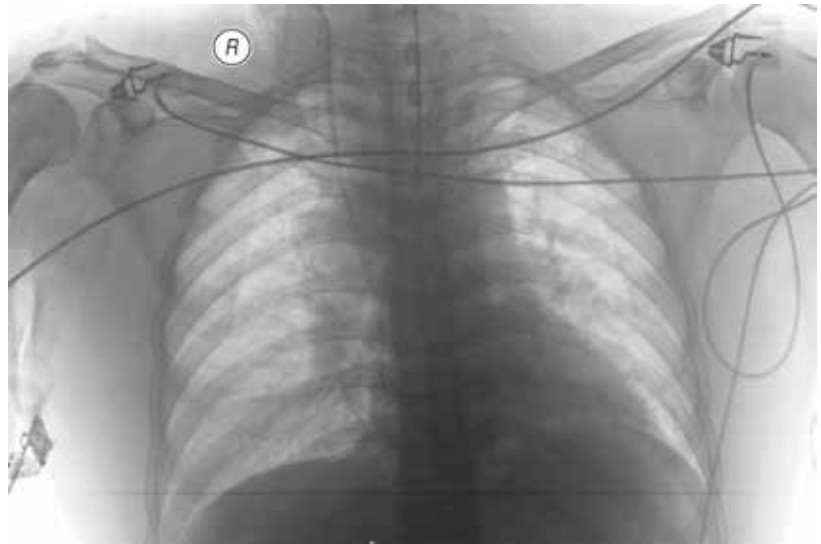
Chest X-ray post stenting
